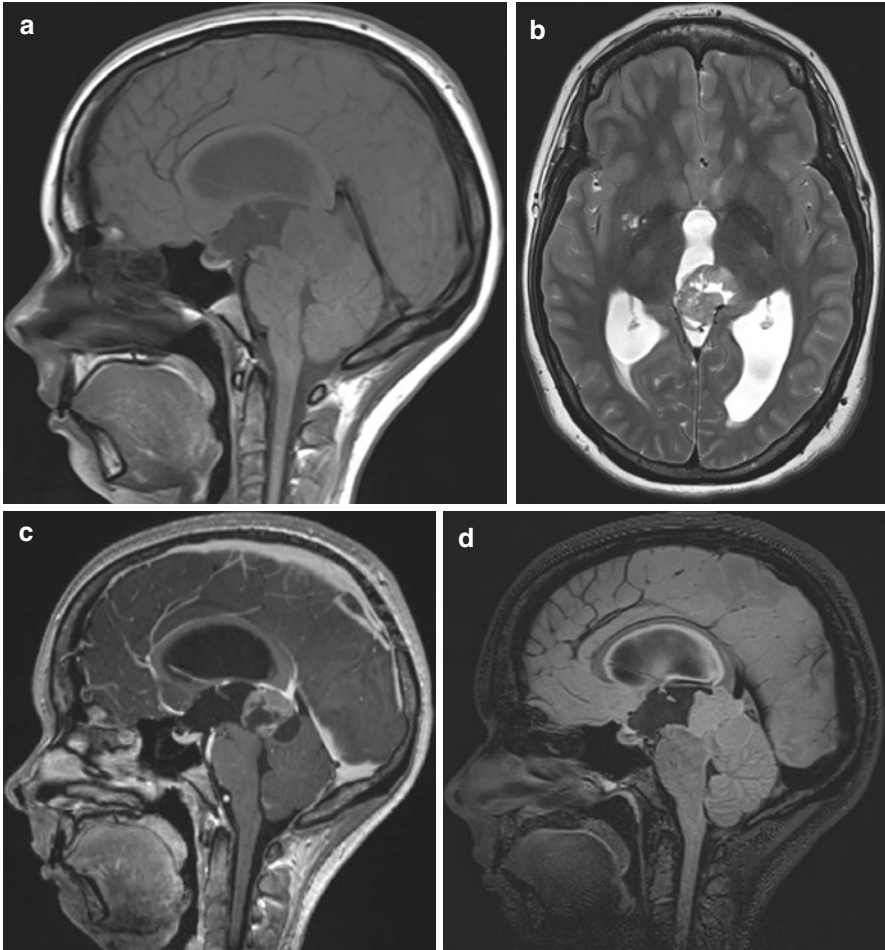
PPTID in T1WI (a), T2WI (b), T1WI with contrast (c), and FLAIR (d) MRI sequences
